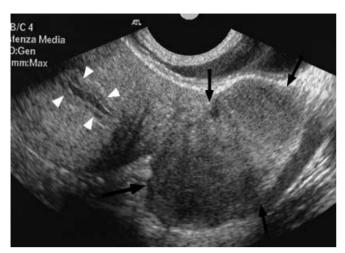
Transvaginal imaging of patient with pelvic inflammatory disease. Ultrasound shows slight dilatation of the endometrial cavity, which contains echogenic fluid, and is surrounded by slightly thickened endometrium (*arrowheads*). In the left adnexal region there is a large solid mass, a tubo-ovarian complex (*arrows*). Tenderness was elicited in this region by positioning of the US transducer
